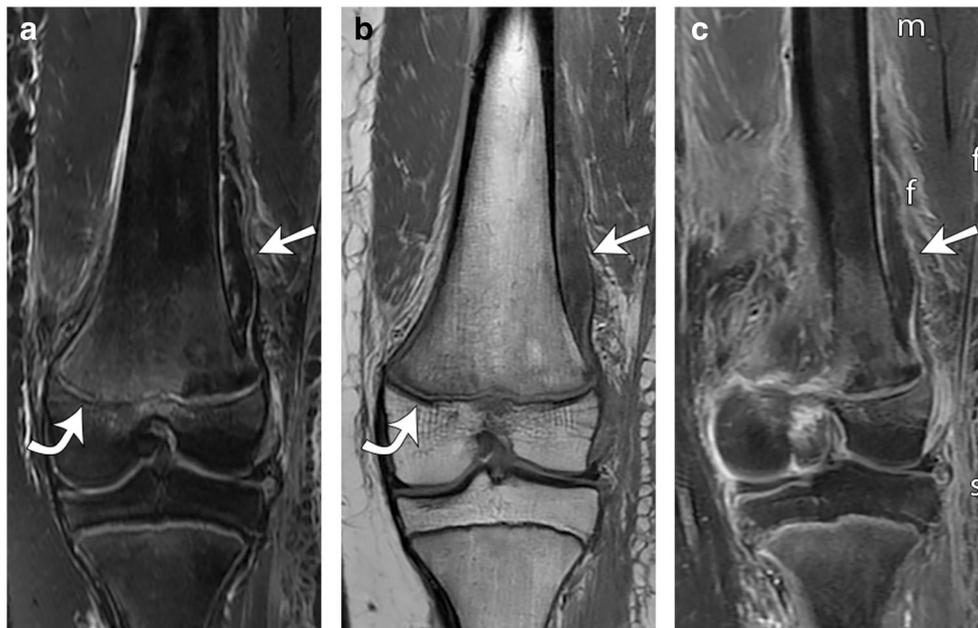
An 11-year-old girl presents with fever 6 days after suffering a distal femoral Salter–Harris type IV fracture. a Coronal fluid-sensitive (T2-weighted fat-suppressed) image of the knee showed the distal femoral physal injury (curved arrow) and a low-signal subperiosteal fluid collection (arrow). Because superinfection of a subperiosteal hematoma was a possibility and because there was increased signal in all anatomic spaces, the case was given a “possible infection” diagnosis, as infection
